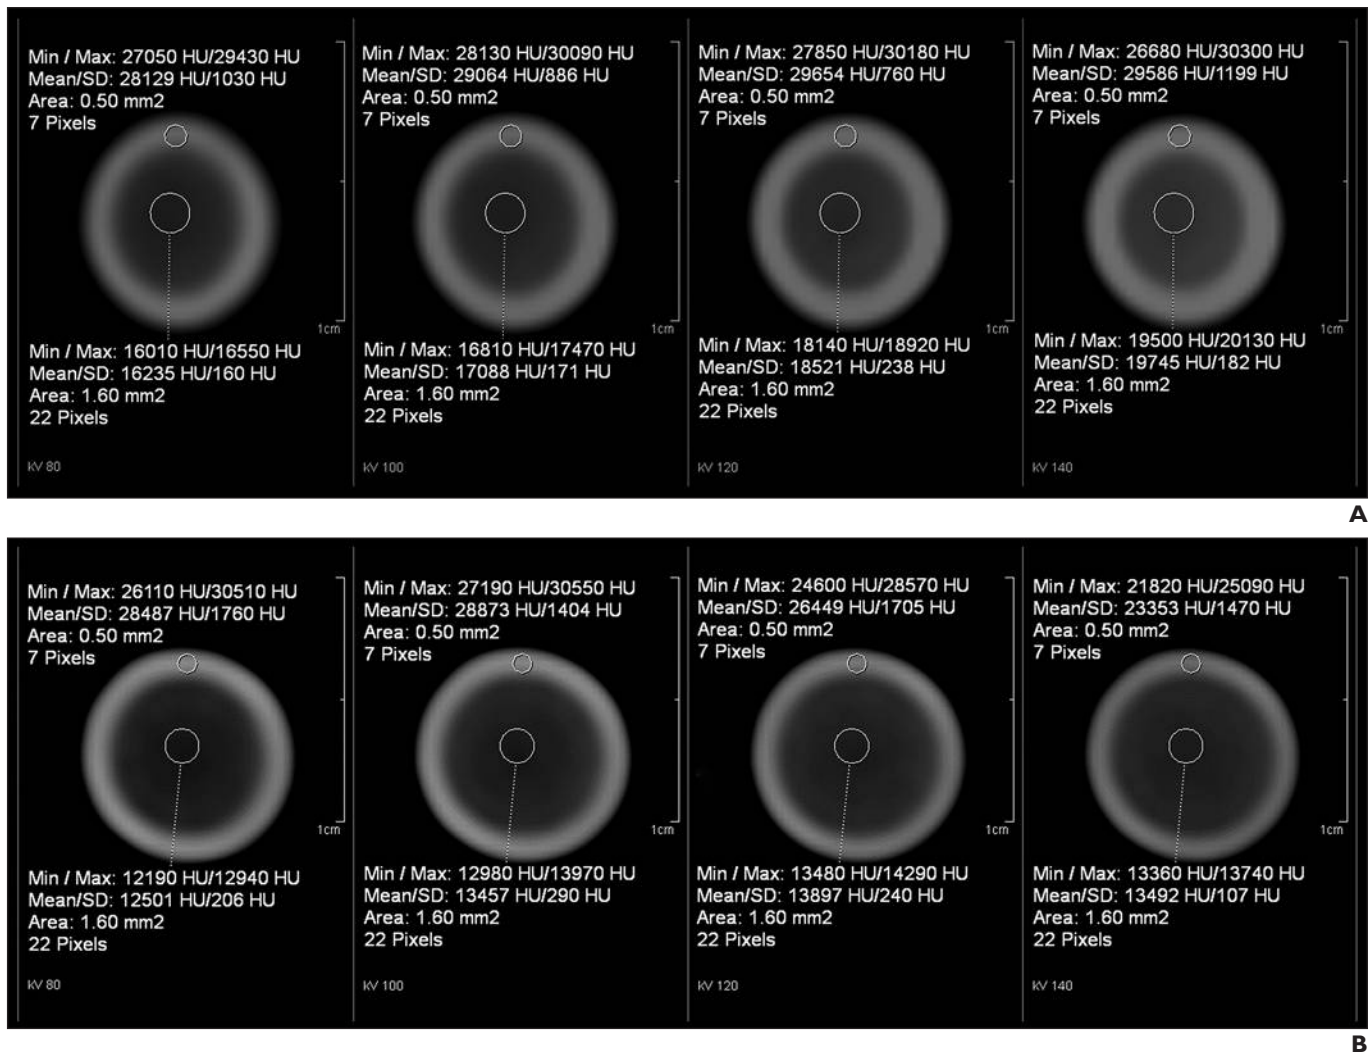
CT images show attenuation measurements in ROIs at center and edge of bullets.
